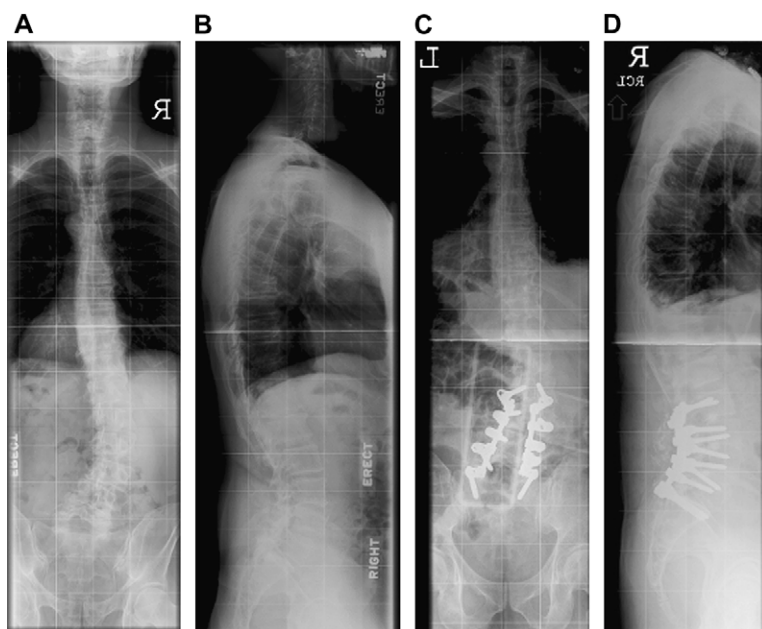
A 62-year-old man with degenerative scoliosis had initially undergone limited decompression that led to collapse and progression of the deformity and worsening of symptoms. Preoperative AP (A) and lateral (B) radiographic views show a lumbar curve of 32° with good coronal and sagittal balance. Decompression and posterior spinal fusion from L2 to the sacrum were performed. The horizontal vertebra was used as the upper instrumented vertebra to save levels because of the patient's activity level. Postoperative AP (C) and lateral (D) radiographic views show maintenance of coronal and sagittal balance and physiologic lumbar lordosis.
